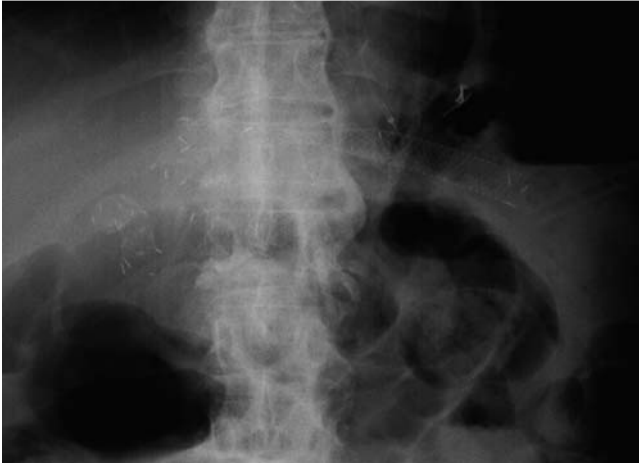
Radiographic image showing the position of the self-expandable metal stent (SEMS) after endoscopic ultrasound (EUS)-guided hepaticogastrostomy in a patient with cancer of the pancreatic head who had previously undergone pancreaticoduodenectomy and hepaticojejunostomy.
